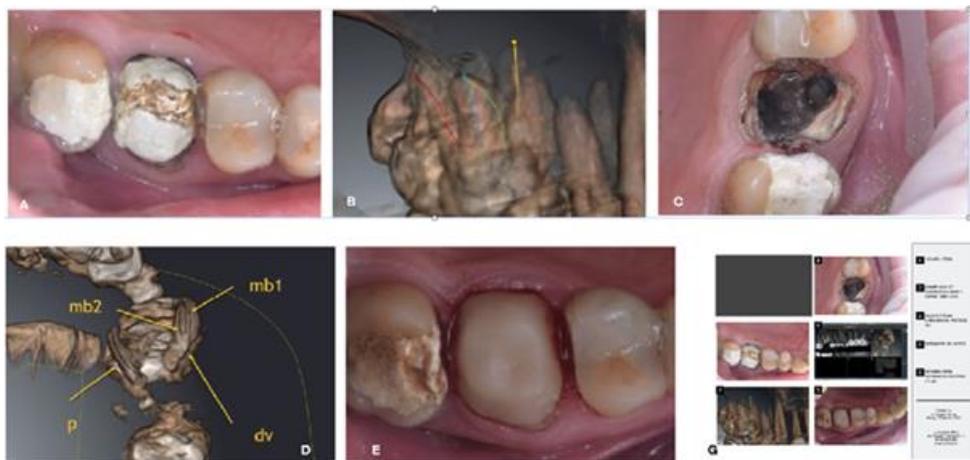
Example of photo portfolio used to create a medical report for the referral dentist. A: initial situation, B: 3D Xray showing an upper first molar with four canals, C: situation after removing the metallic post, D: 3D Xray control validating the quality of root canals obturation, E: clinical image with new ceramic post core, G: example of report created with the images
